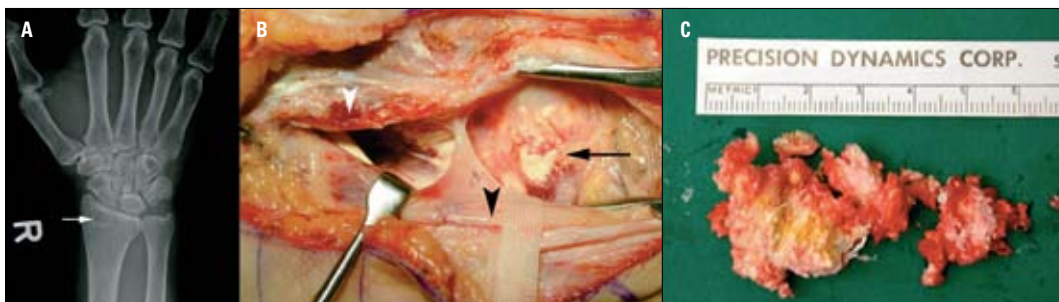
X-ray of right wrist demonstrating erosion into the distal radius (white arrow)
